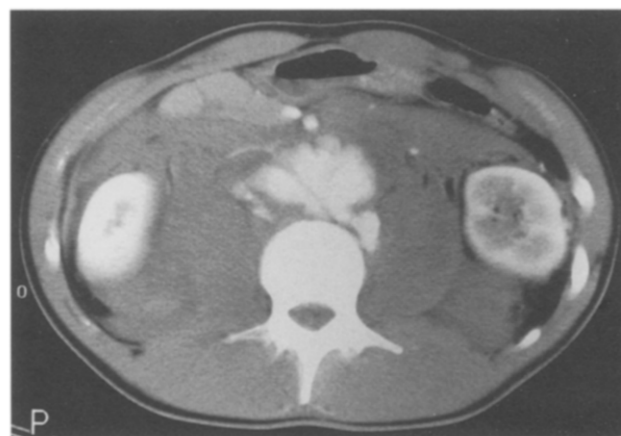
CT scan with intravenous contrast demonstrating gross extravasation of contrast from the infrarenal aorta.
